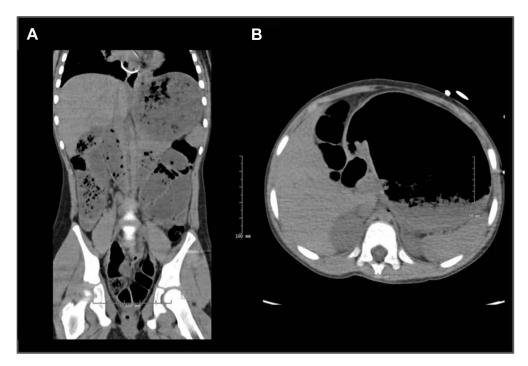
Coronal (A) and axial (B) computed tomography images demonstrate prominent gastric and bowel distention. (A) also demonstrates intra-esophageal looping of the nasogastric tube.
